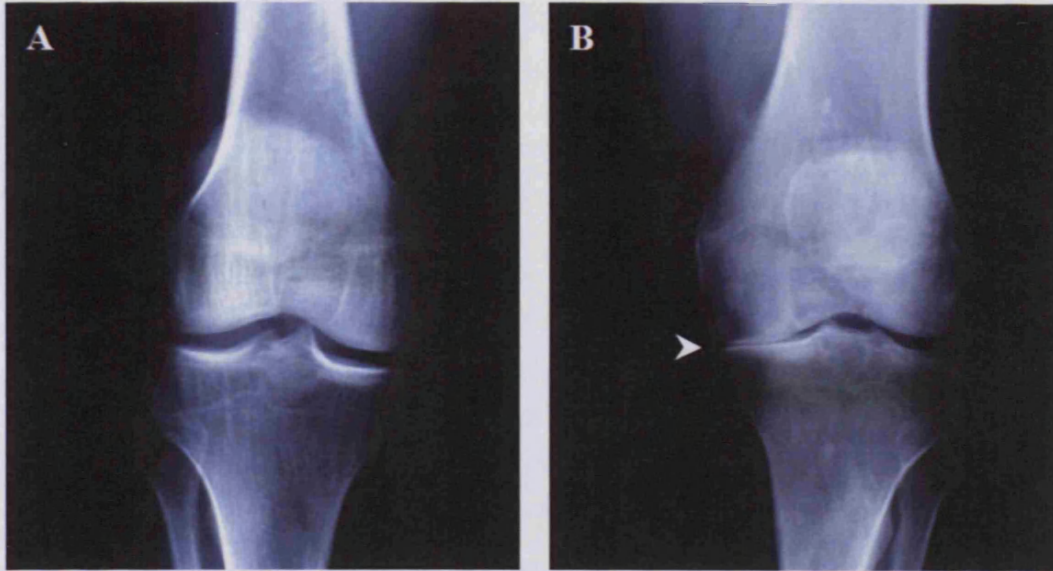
Radiographic images of a normal (A) and an osteoarthritic knee joint requiring total knee replacement surgery (B). Joint space narrowing (white arrow head) indicates a severe loss of articular cartilage. Images are from meded.ucsd.edu/clinicalmed/joints.htm
